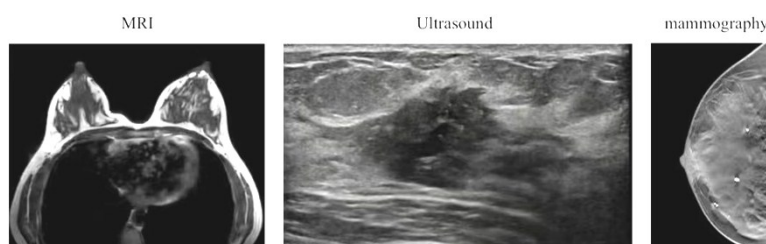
The BI-RADS grade of MRI, ultrasound, mammography and was 4A.
